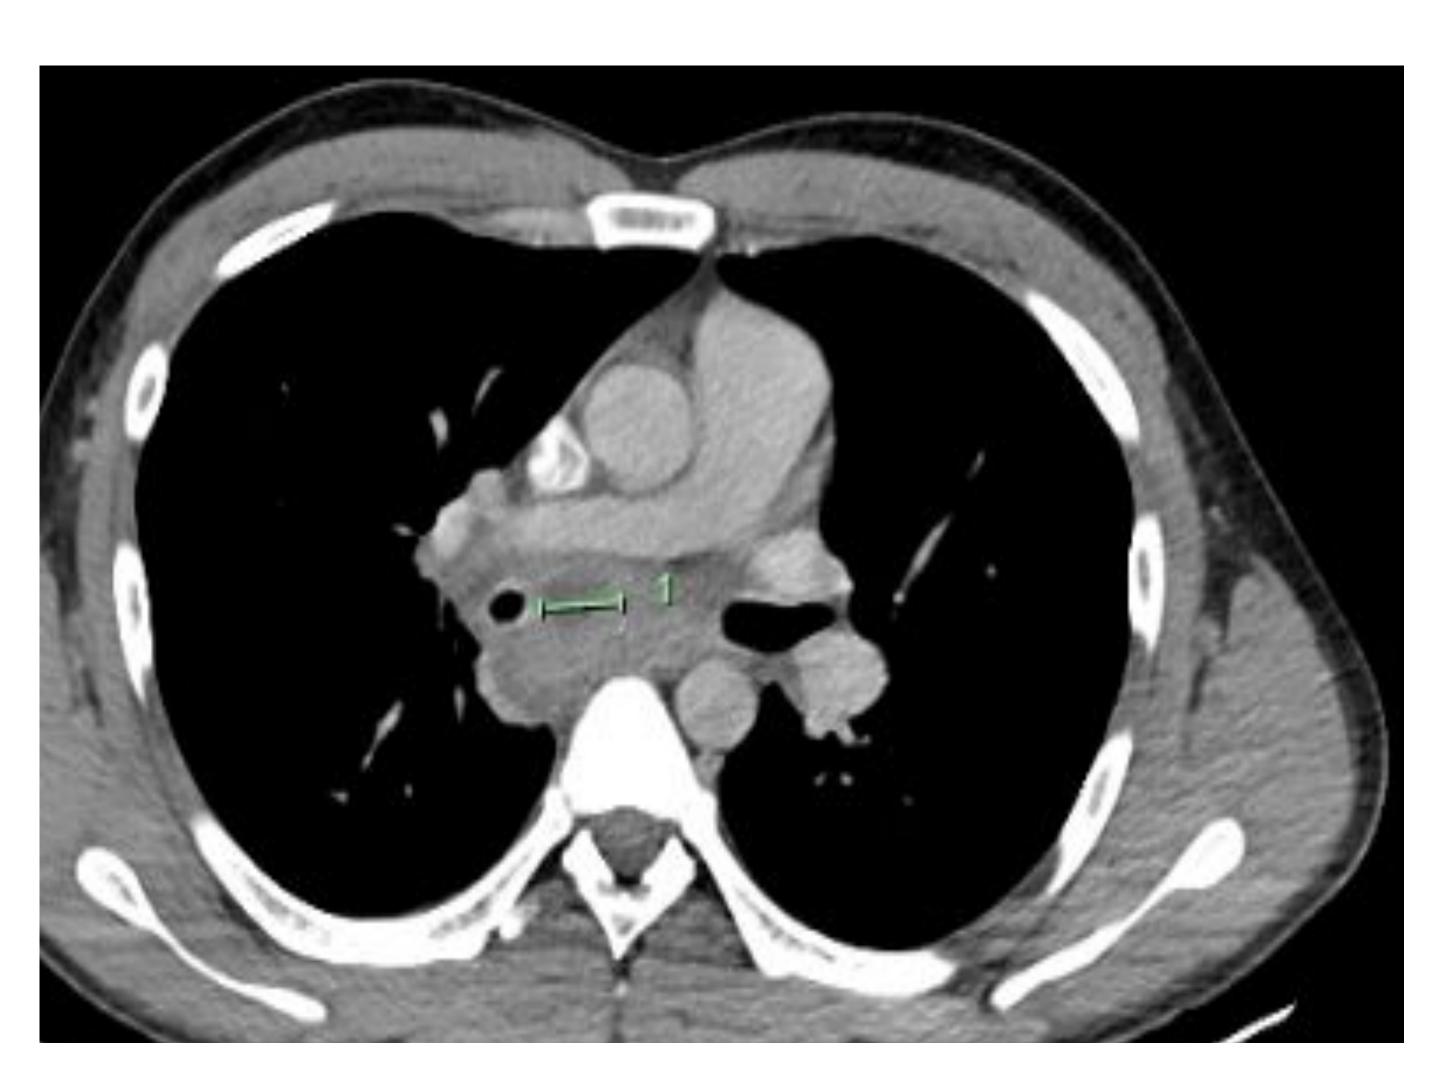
Axial CT of the chest demonstrating a 2.2 cm subcarinal phlegmon with central necrosis
